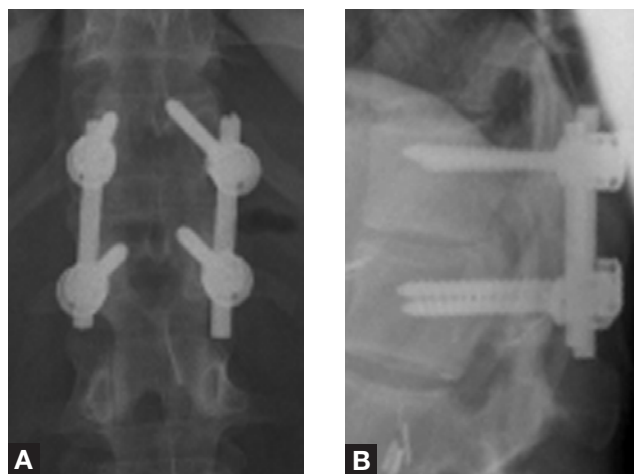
Final follow-up anteroposterior (A) and lateral (B) postoperative x-rays of thoracolumbar junction after reduction and T12–L1 instrumented fusion with iliac crest bone graft. Solid fusion is noted. Instrumentation consists of posteriorly inserted pedicle screws and rods placed in compression to maintain anatomical reduction of the facet complex.
